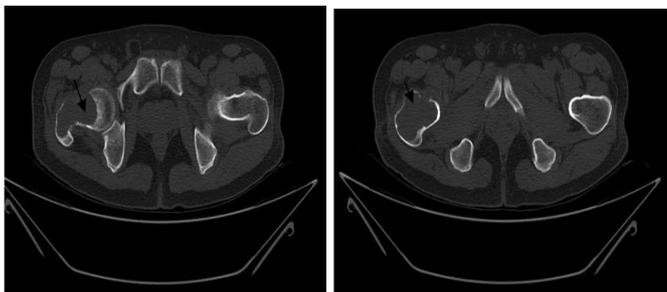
CT- scan showing extent of the lesion
